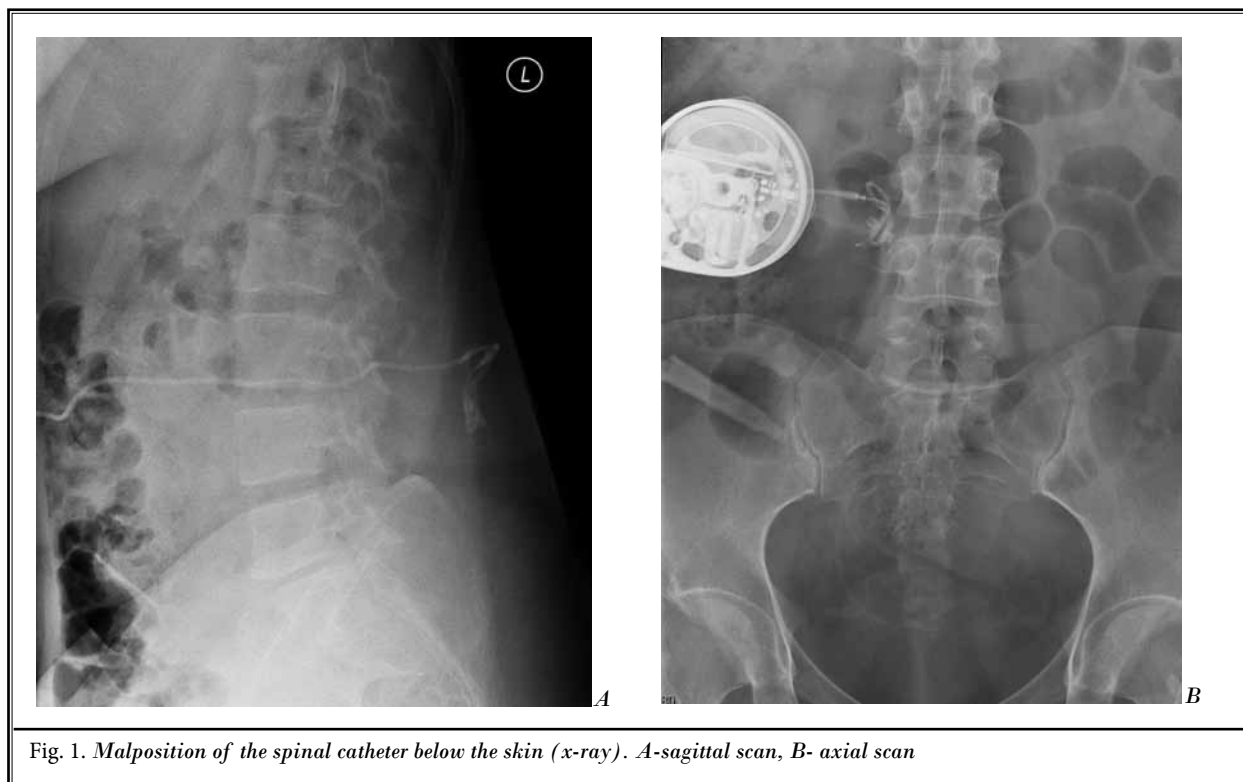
Malposition of the spinal catheter below the skin (x-ray). A-sagittal scan, B- axial scan
